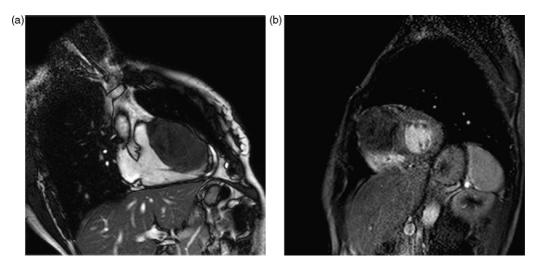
(a) MRI SSFP sequence. Right ventricular outflow tract. Homogeneous and iso-intense to myocardial wall soft tissue mass, without any calcification detected. (b) First pass perfusion MRI. Poor enhancement of the mass.
